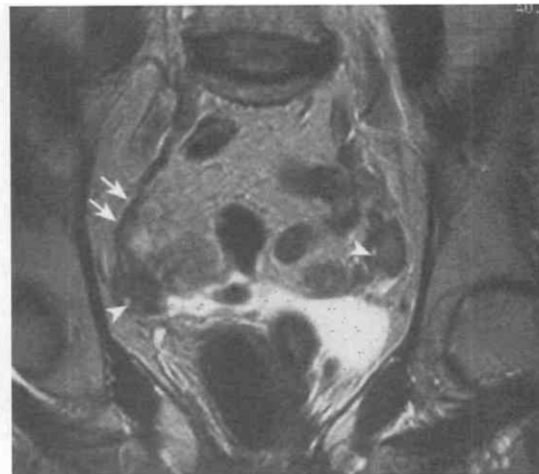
Normal postmenopausal ovaries. Coronal T2-weighted, fast spin-echo image (TR = 4000, TE_{eff} = 140 msec) demonstrates small, low-signal-intensity ovaries. The ovarian vessels leading to the right ovary (arrows) and the presence of a tiny follicular cyst in each ovary (arrowheads) identify these structures as ovaries. (For reference, a 5-cm scale is on right side of image). TE_{eff}, effective echo time.
